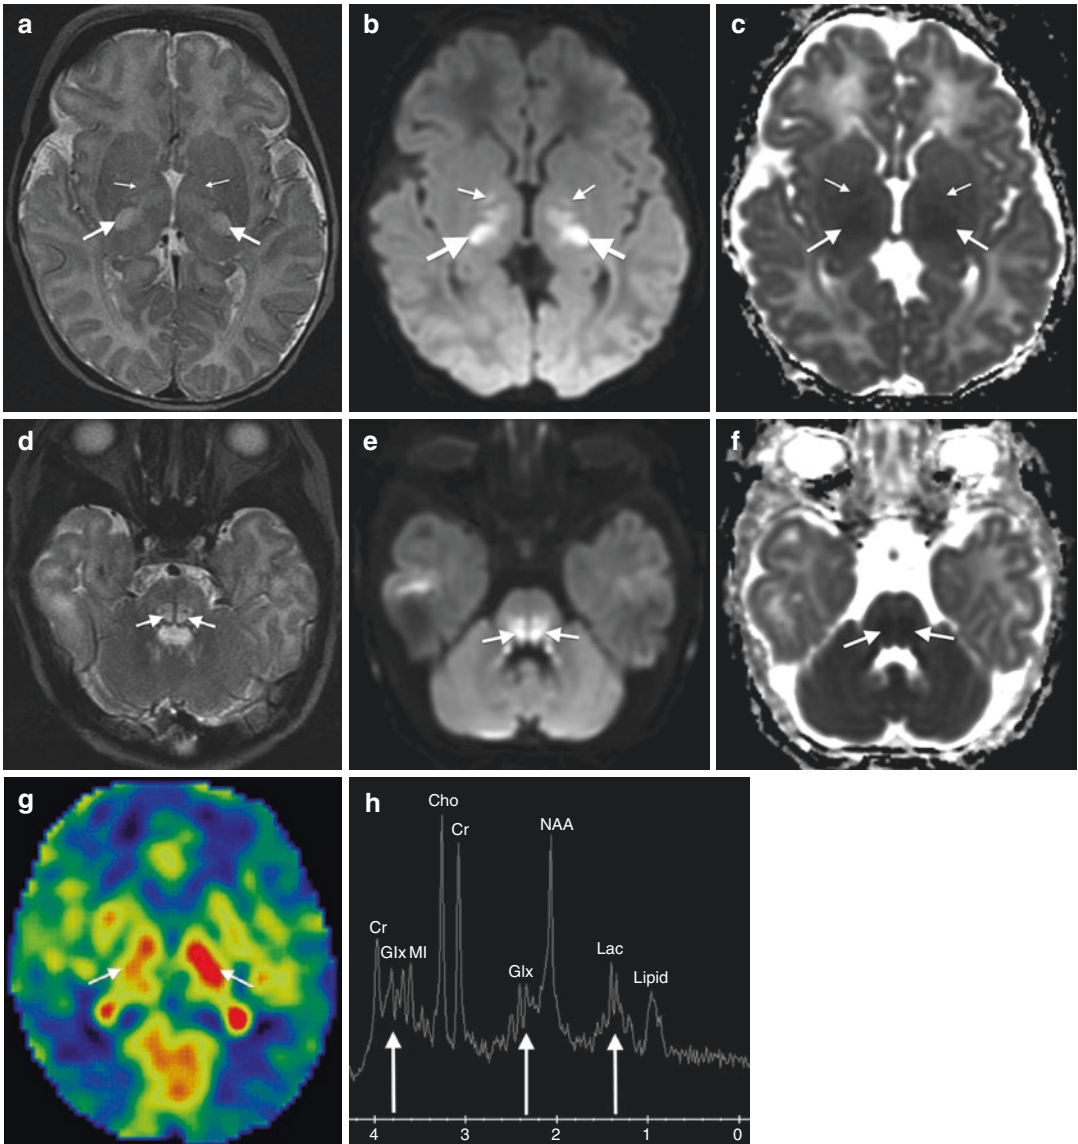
48-day-old female with Leigh disease. Axial T2WI (TR/TE ms, 3500/120) (a), DWI (TR/TE ms, 8000/85) (b), and ADC (TR/TE ms, 8000/85) (c) images through the cerebral deep gray nuclei. T2 prolongation and reduced diffusion are present in the thalami (*large arrows, a–c*) and globi pallidi (*small arrows, a–c*). Axial T2WI (d), DWI (e), and ADC (f) images through the pons show T2 prolongation, swelling, and reduced diffusion
